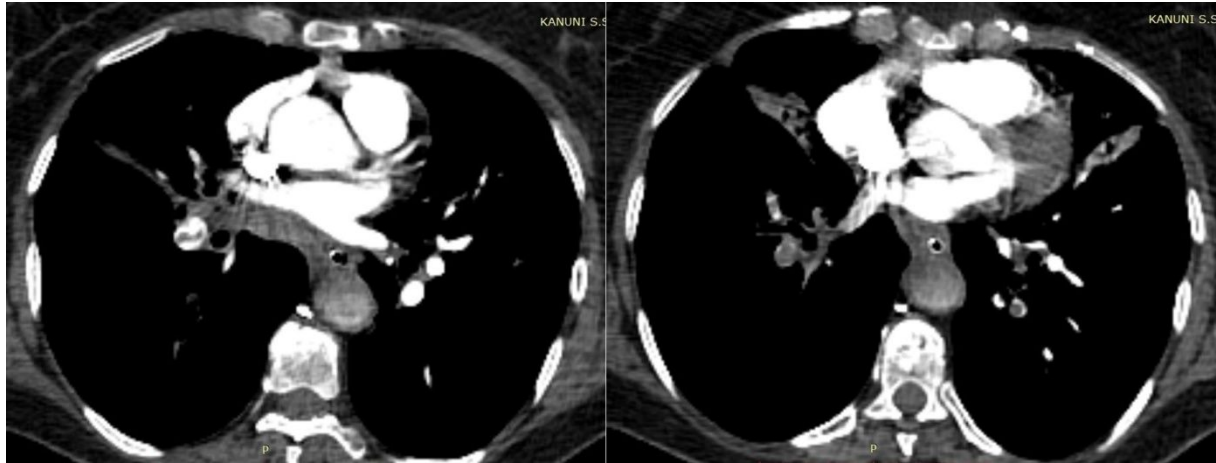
Thoracic CT Angiography (Pulmonary Embolism causing filling defects in bilateral pulmonary artery branches)
